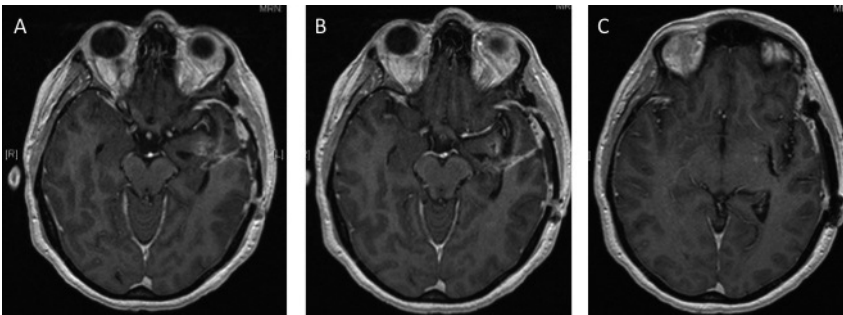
A, B, C) 1-month MRI after the second operation that shows neither residual nor recurrence of the tumor.
